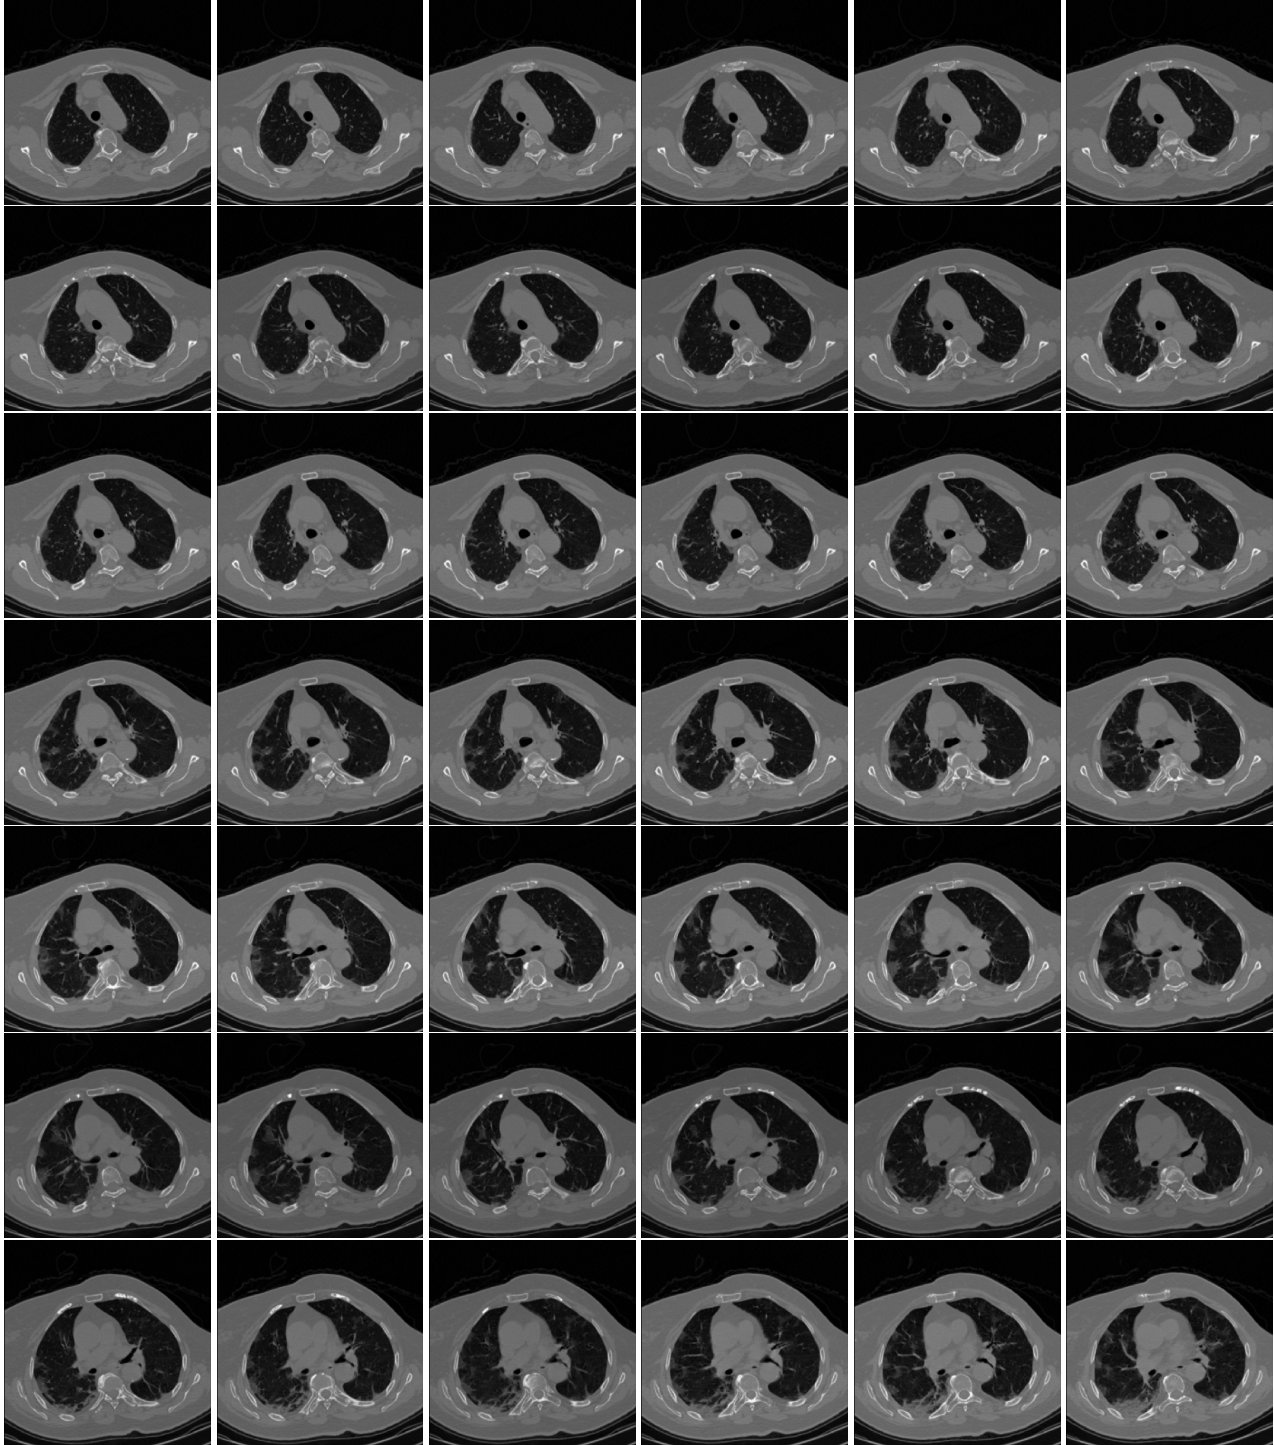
Slices from a COVID-19 CT scan.
